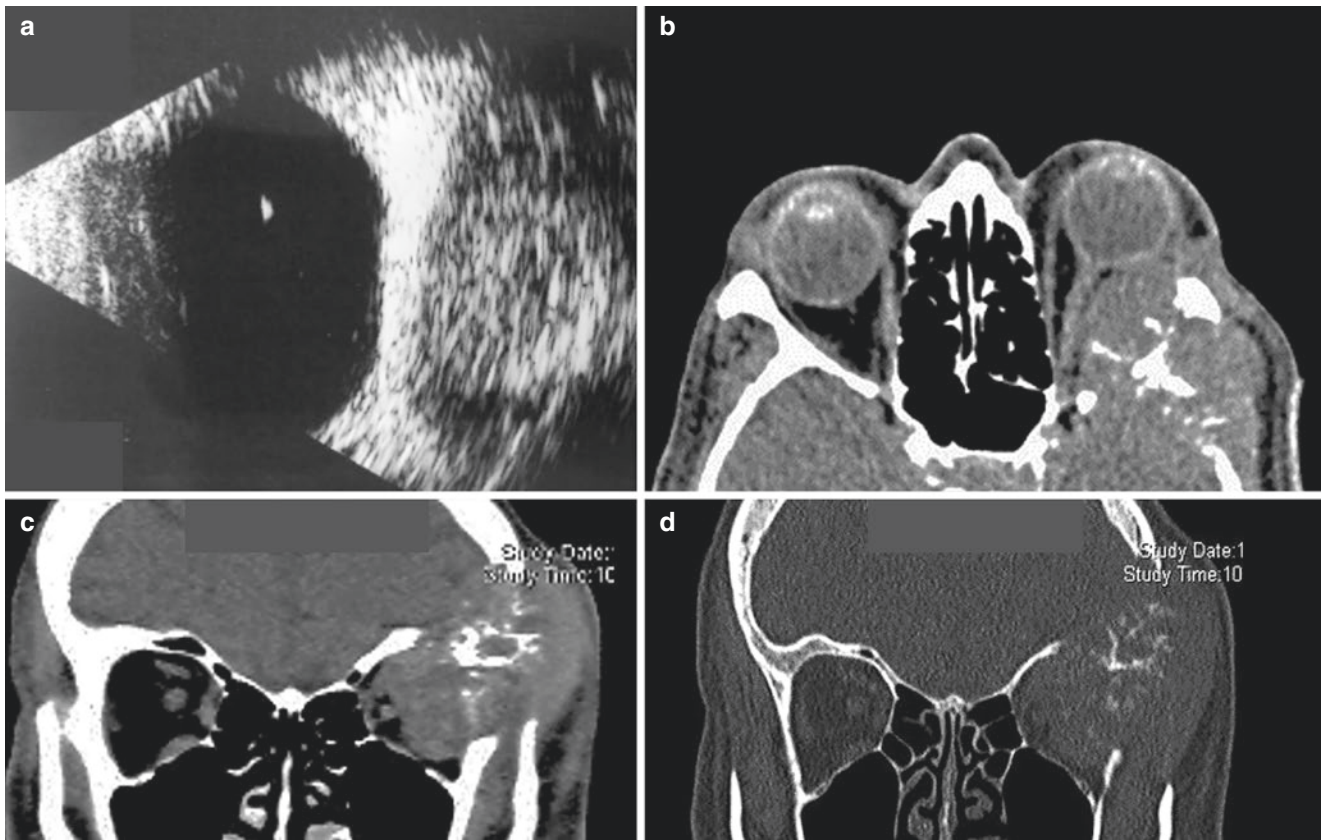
(a): Ultrasound B-scan showing heterogeneous high reflective retrobulbar mass with globe indentation. Axial (b) coronal (c) contrast-enhanced CT scan shows a large mass centred on the left sphenoid wing, expanding into the orbit, middle cranial fossa and temporal
